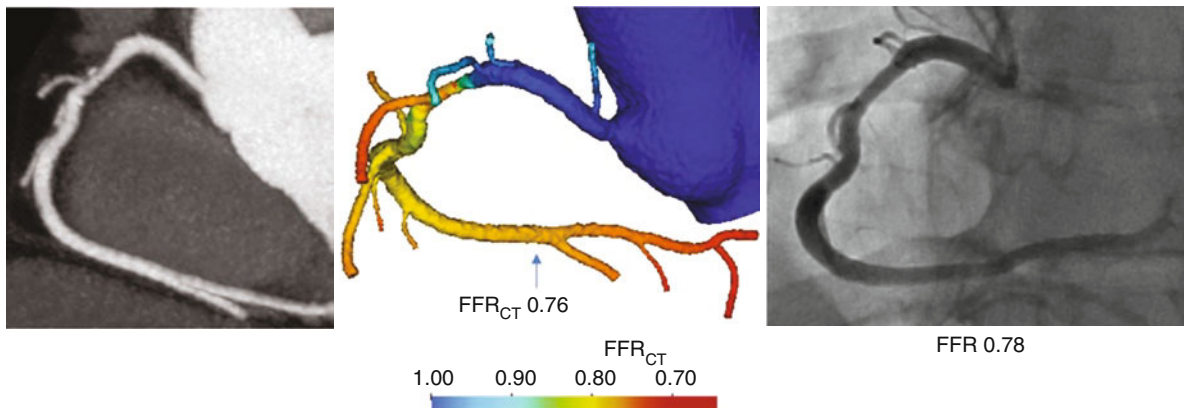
Computation of  $FFR_{CT}$  is contingent on adherence to image acquisition guidelines and good image quality. Sublingual nitroglycerin is necessary for arterial visualization. Artifacts from excess cardiac motion, breathing, calcium “blooming,” inadequate contrast opacification, or incomplete acquisition of all myocardial tissue may preclude  $FFR_{CT}$  calculation
